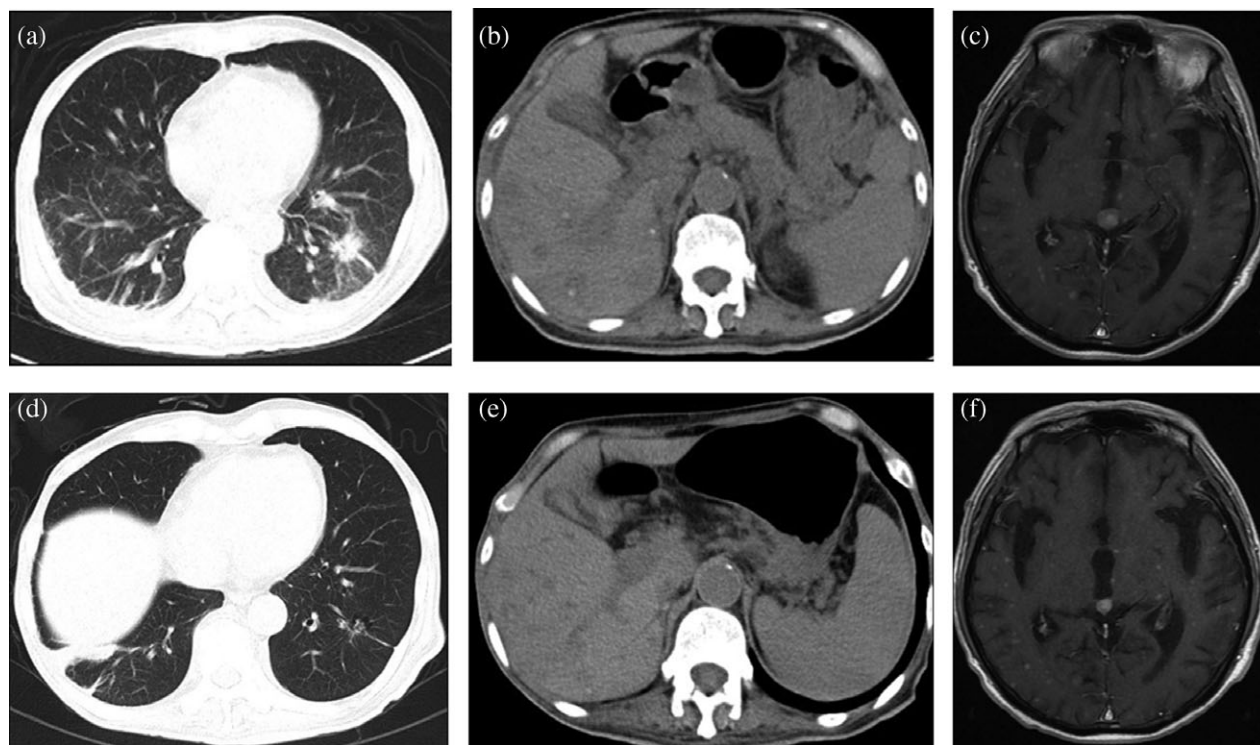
The radiographic response of the patient's primary lung tumor and metastases (a,b,c) before and (d,e,f) after ceritinib treatment. The computed tomography (CT) scan taken before ceritinib treatment showed a solid pulmonary lesion in the (a) left inferior lobe of the lung and (b) multiple liver lesions, and (c) contrast-enhanced magnetic resonance imaging (MRI) of the head showed multiple brain metastatic lesions. The CT scan and contrast-enhanced MRI of the head after four weeks of ceritinib treatment showed that (d) the primary lung tumor, (e) multiple liver lesions, and (f) brain metastatic lesions were obviously smaller.
